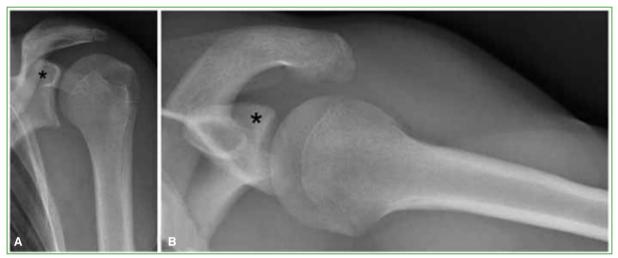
Left-shoulder radiographs of the same patient, anteroposterior (A) and axial (B) views. A radiolucent line extends from the base of the coracoid to the glenoid articular surface (*), similar to the contralateral side.
